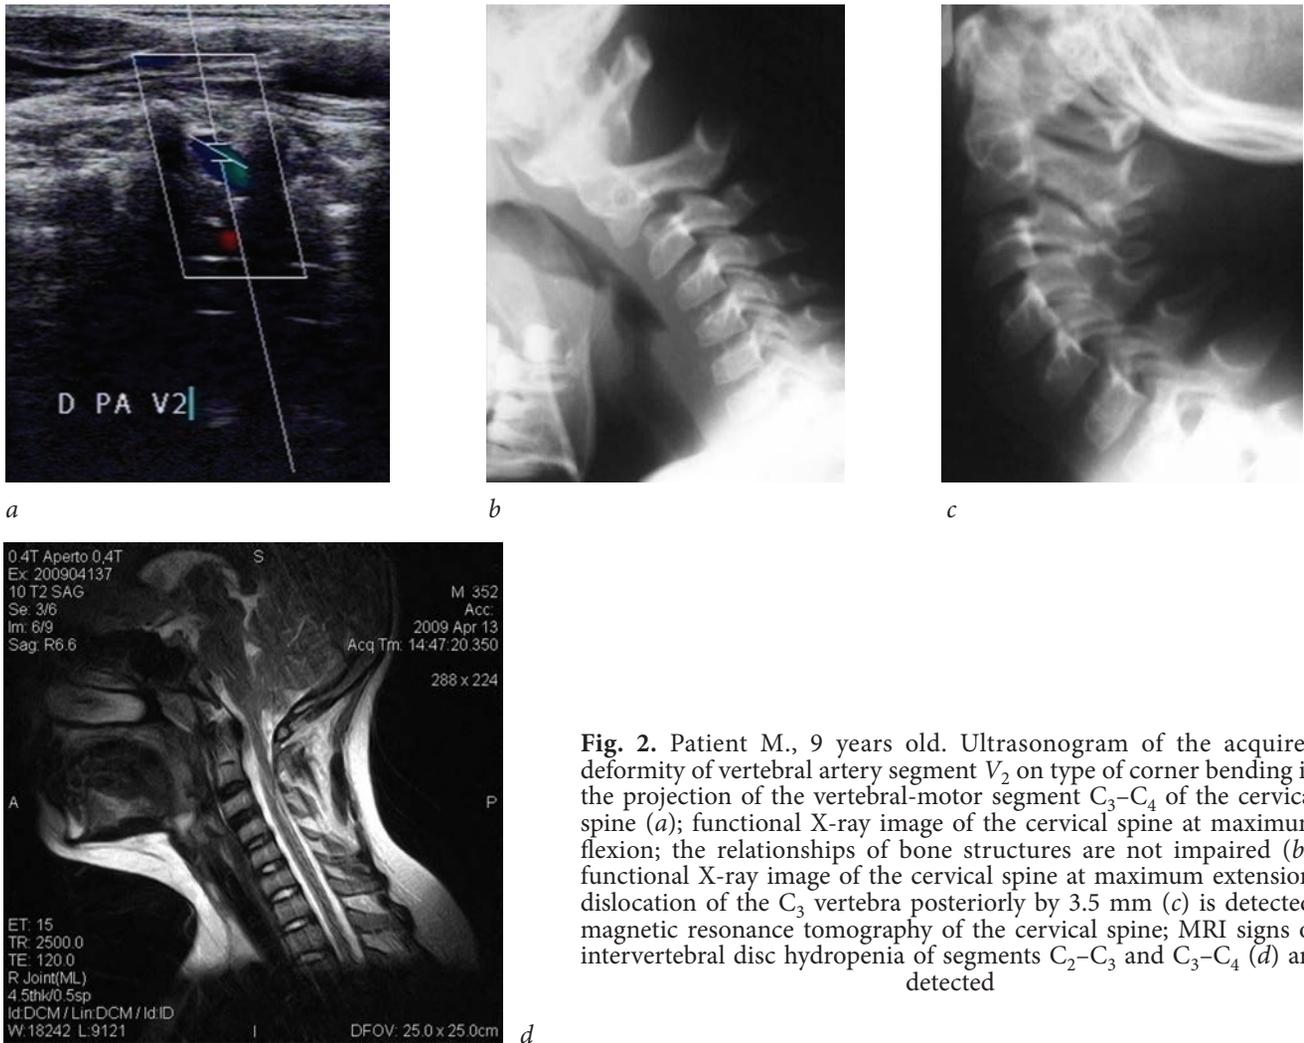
Patient M., 9 years old. Ultrasonogram of the acquired deformity of vertebral artery segment V_2 on type of corner bending in the projection of the vertebral-motor segment C_3-C_4 of the cervical spine (a); functional X-ray image of the cervical spine at maximum flexion; the relationships of bone structures are not impaired (b); functional X-ray image of the cervical spine at maximum extension; dislocation of the C_3 vertebra posteriorly by 3.5 mm (c) is detected; magnetic resonance tomography of the cervical spine; MRI signs of intervertebral disc hydroponia of segments C_2-C_3 and C_3-C_4 (d) are detected
